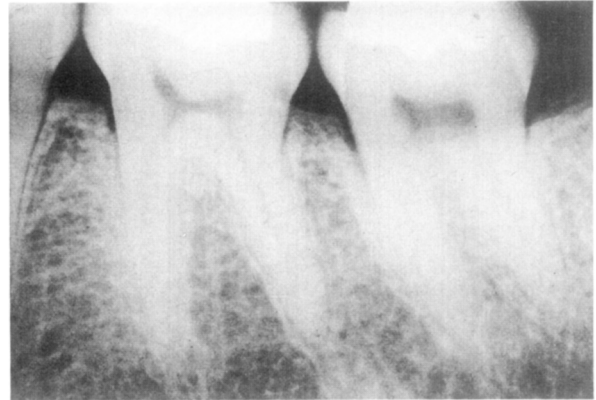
Periapical radiograph of mandibular left molar region.
